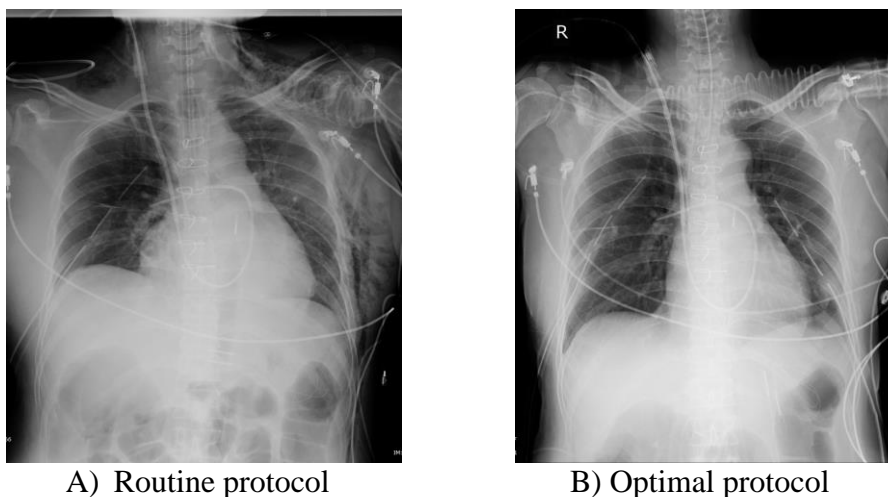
Chest radiographs from routine and optimal protocol
